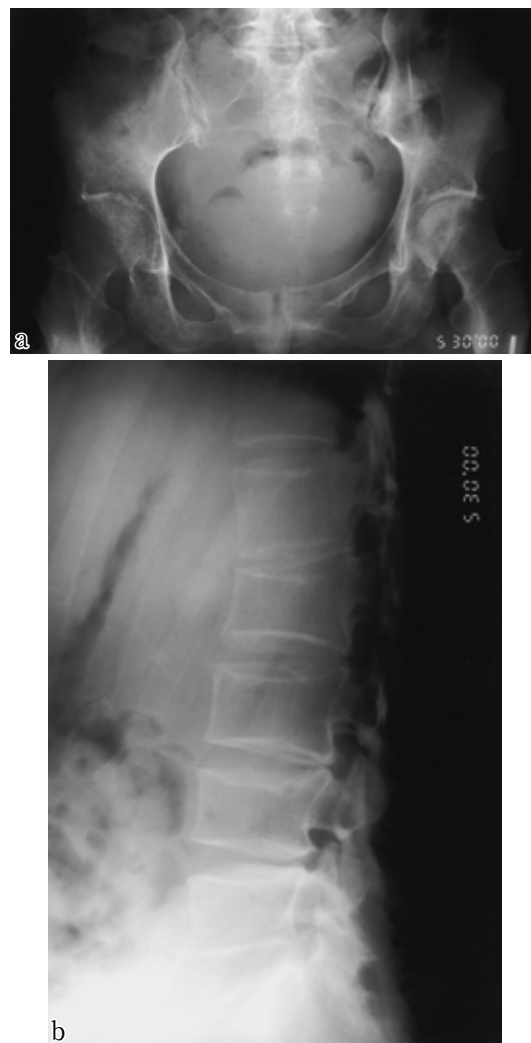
X-ray examination after delivery in case 1 (8 weeks after onset)
